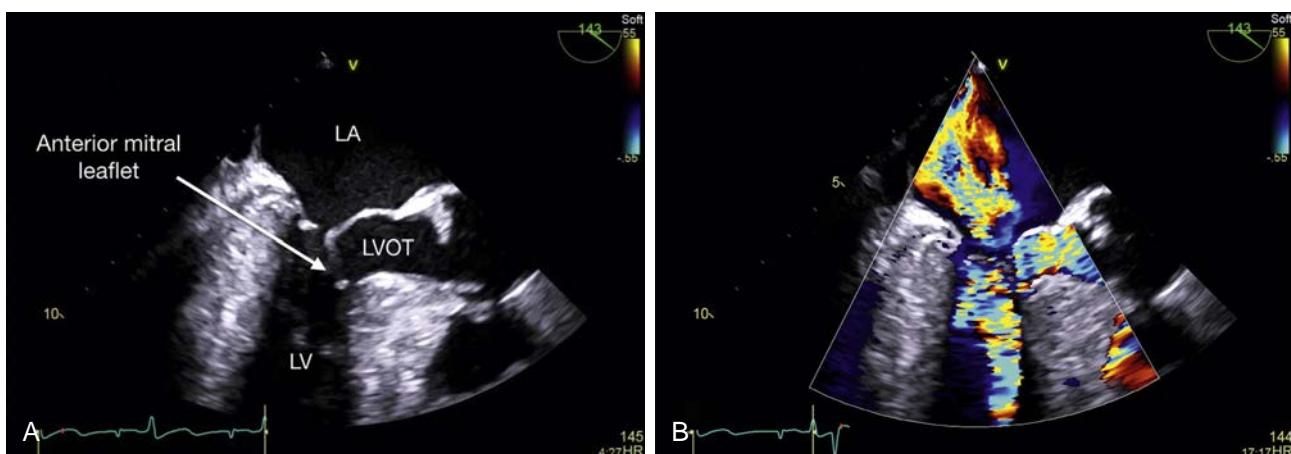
Midesophageal long axis views without (A) and with color (B) demonstrating systolic anterior motion of the mitral valve (SAM). (A) Instead of coapting normally, the anterior mitral leaflet (arrow) moves into the left ventricular outflow tract (LVOT) during systole. This narrows the effective outflow tract and can lead to dynamic obstruction to flow. (B) Turbulent flow is visualized by color Doppler in the LVOT. In this example, there is significant mitral regurgitation associated with SAM. LA, Left atrium; LV, left ventricle.
